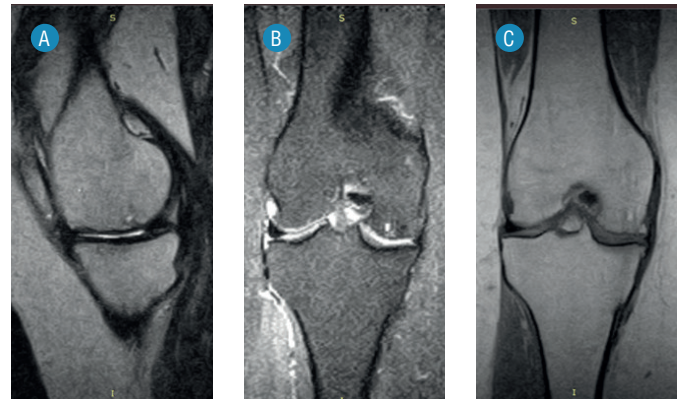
MRI of the right knee of a 52-year-old female patient with aseptic osteonecrosis of the medial femoral condyle, Ficat stage I, 12 months after treatment with regenerative interventional technologies (details in the text).
